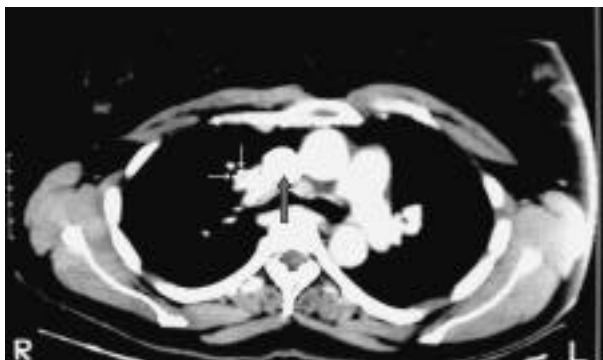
Computed tomographic scan of the chest showing a mass on the right side representing lymphadenopathy (narrow arrows) and a superior vena caval thrombus (wide arrow).
